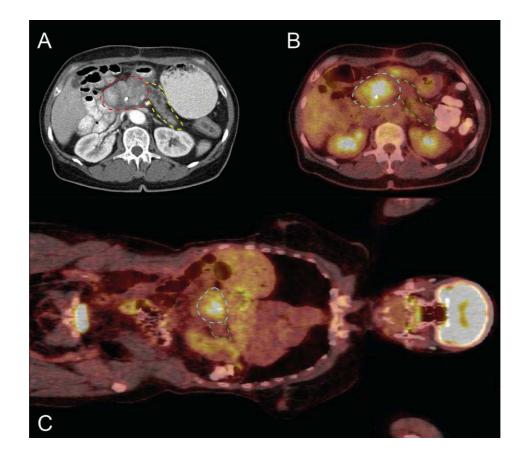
CT (Panel A) and PET (Panels B and C) images of patient 5 showing pancreatic adenocarcinoma prior to treatment. Panel A shows a CT scan in the transverse plane with the primary tumour in the head of the pancreas, and the pancreas indicated by the red and yellow dashed lines respectively. Panels B and C show PET scans in transverse and coronal plane respectively. The location of the tumour can be clearly identified by the brighter colour in the middle of the abdomen. In Panels B and C, the tumour and pancreas are respectively indicated by the blue and green dashed lines. The pancreas tail is behind the large colon in panel C.
